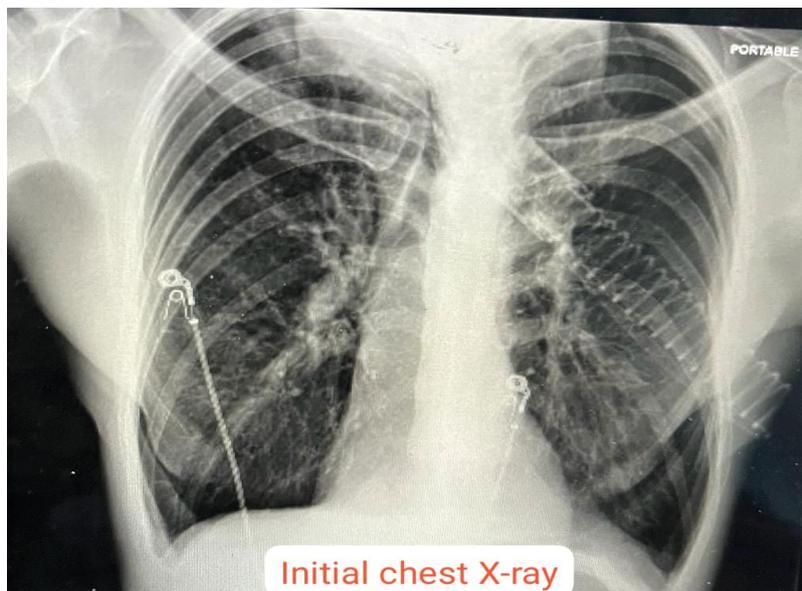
Initial chest X-ray.
